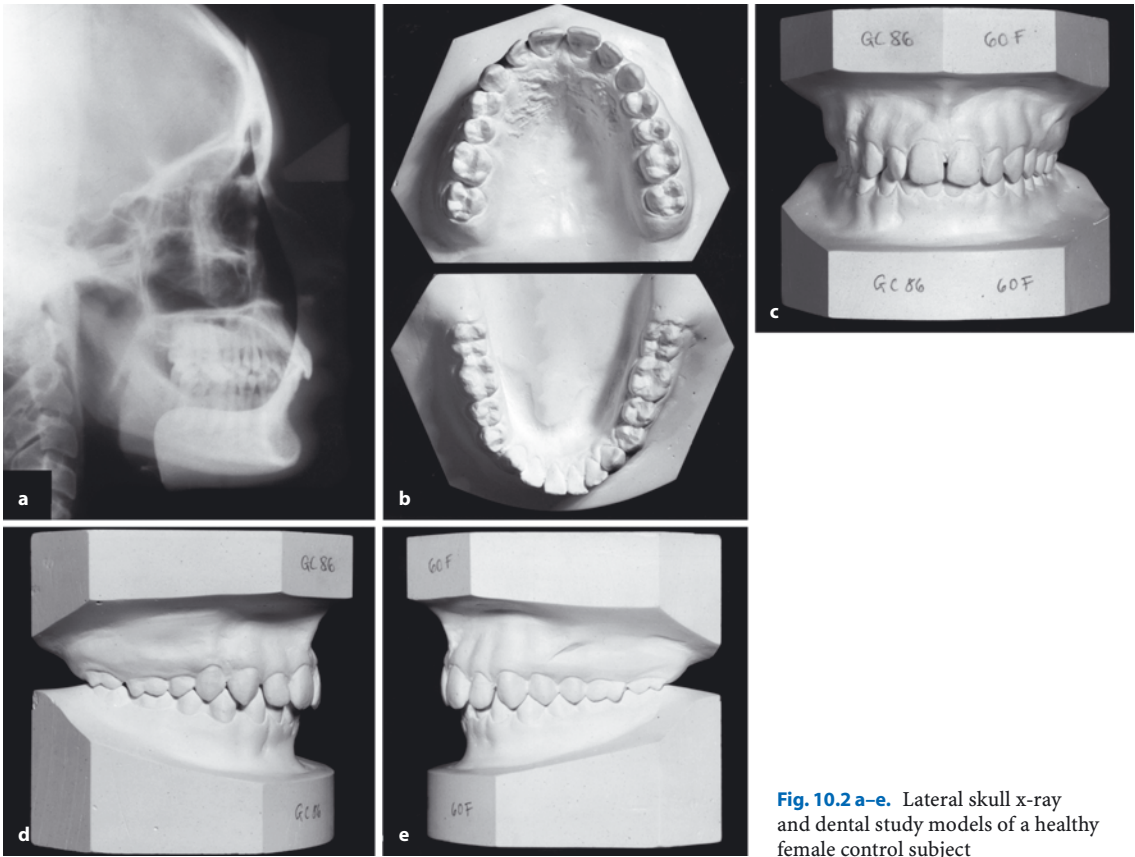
a–e. Lateral skull x-ray and dental study models of a healthy female control subject
